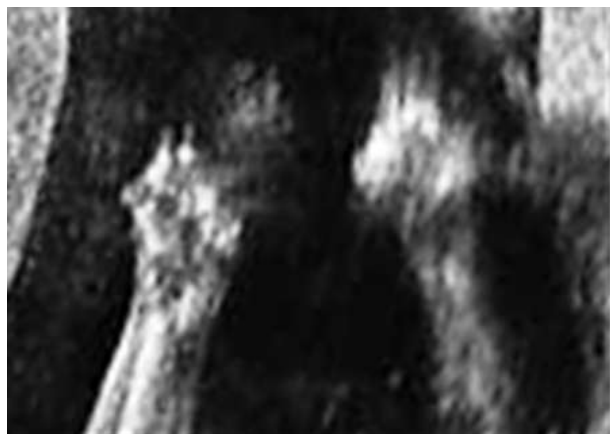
Ultrasound of the fingers showed joint contractures. Such images of the fetal hands are features of clenched hands, and may raise the suspicion of trisomy 18.
